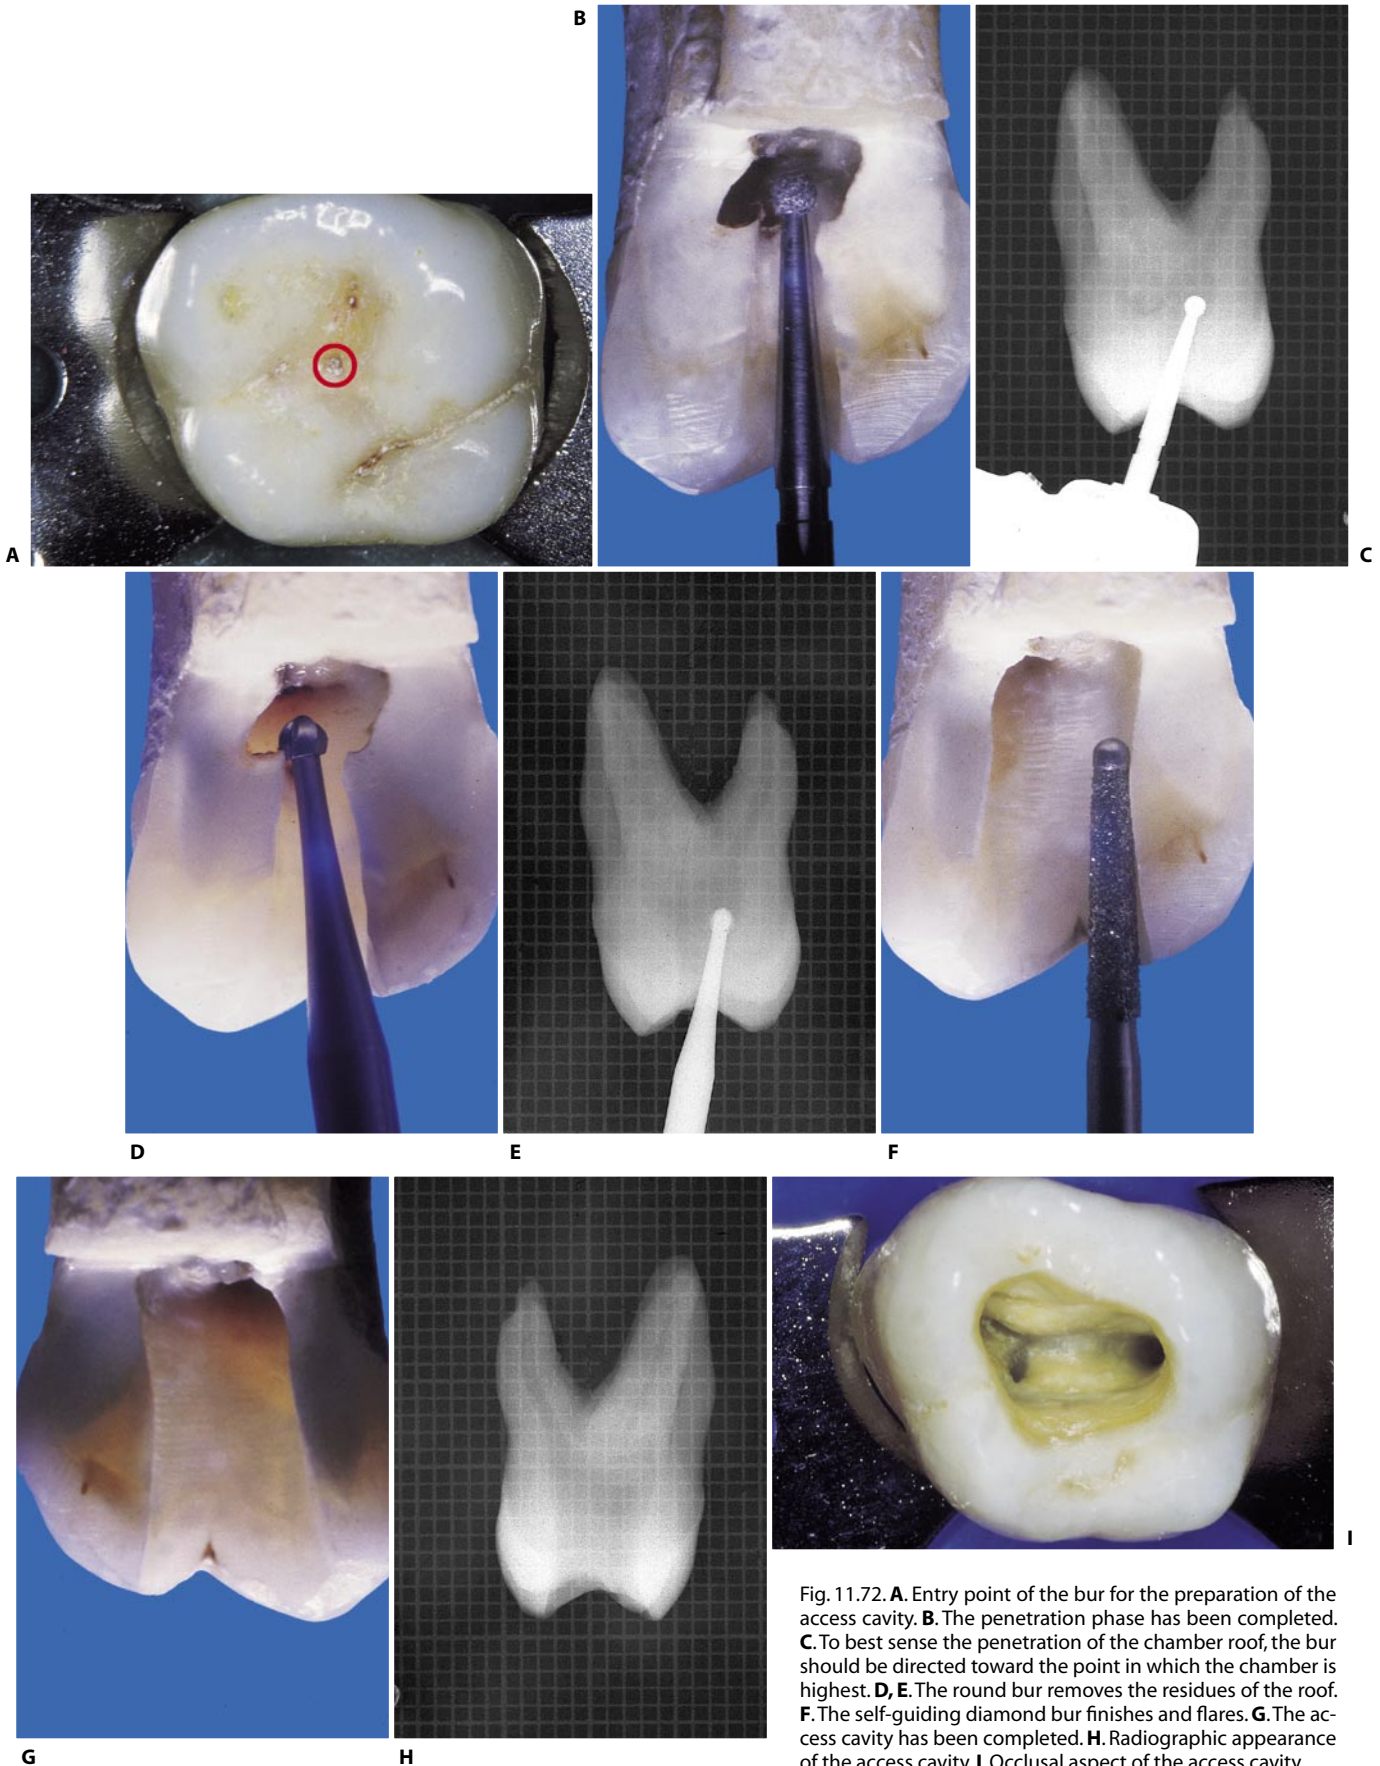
A. Entry point of the bur for the preparation of the access cavity. B. The penetration phase has been completed. C. To best sense the penetration of the chamber roof, the bur should be directed toward the point in which the chamber is highest. D, E. The round bur removes the residues of the roof. F. The self-guiding diamond bur finishes and flares. G. The access cavity has been completed. H. Radiographic appearance of the access cavity. I. Occlusal aspect of the access cavity.
